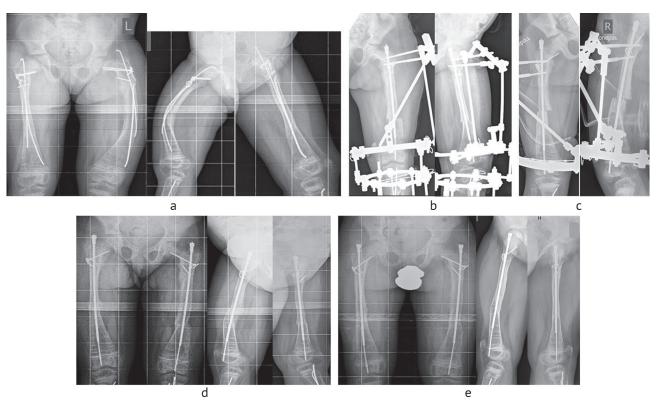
An instance of revision correction of femoral deformities showing (*a*) preoperative radiographs; (*b*) deformity of the left femur being corrected with combined technique; (*c*) deformity of the right femur being corrected with combined technique; (*d*) external fixation devices removed; (*e*) rod telescoping and no signs of migration at 12 months after removal of the frame from the right femur and at 13 months after removal of the frame from the left femur
